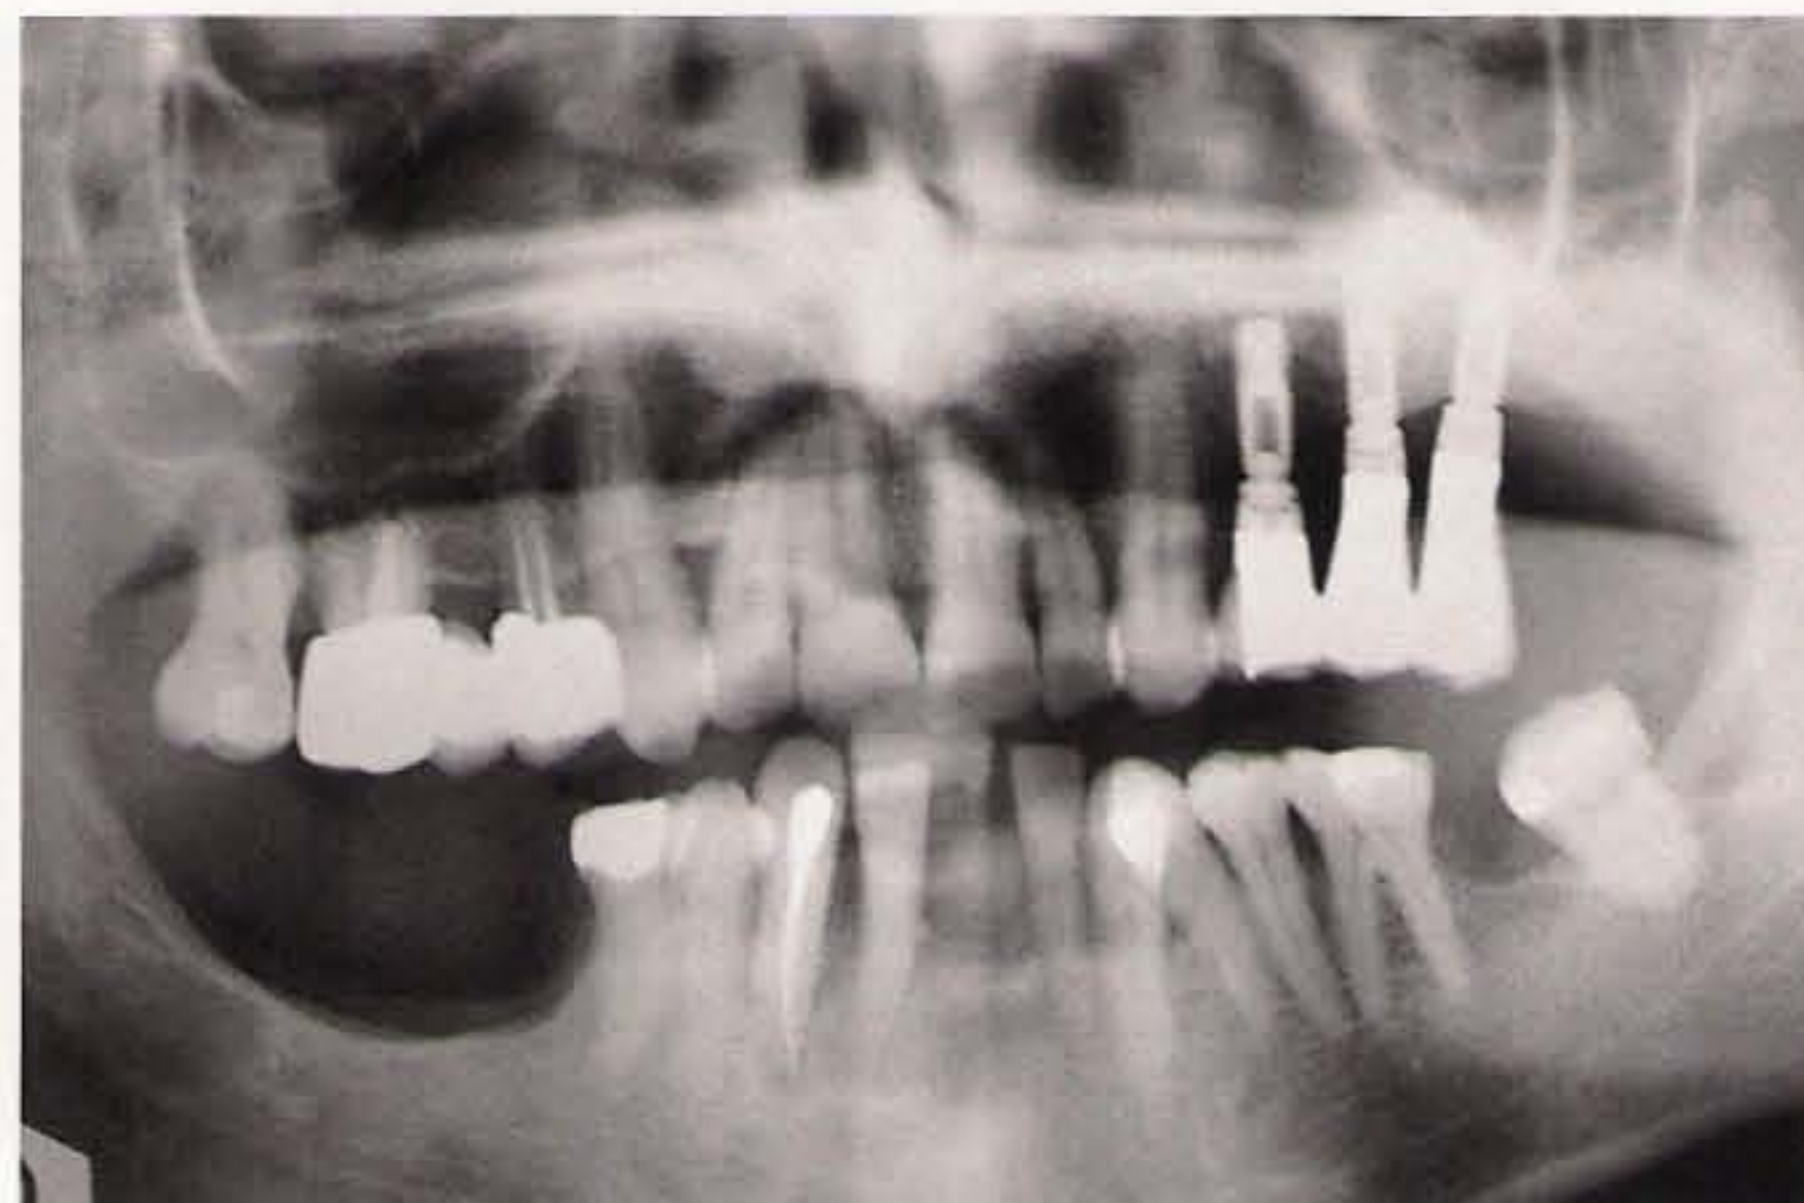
A panoramic radiograph is used to evaluate the completed prosthesis.
